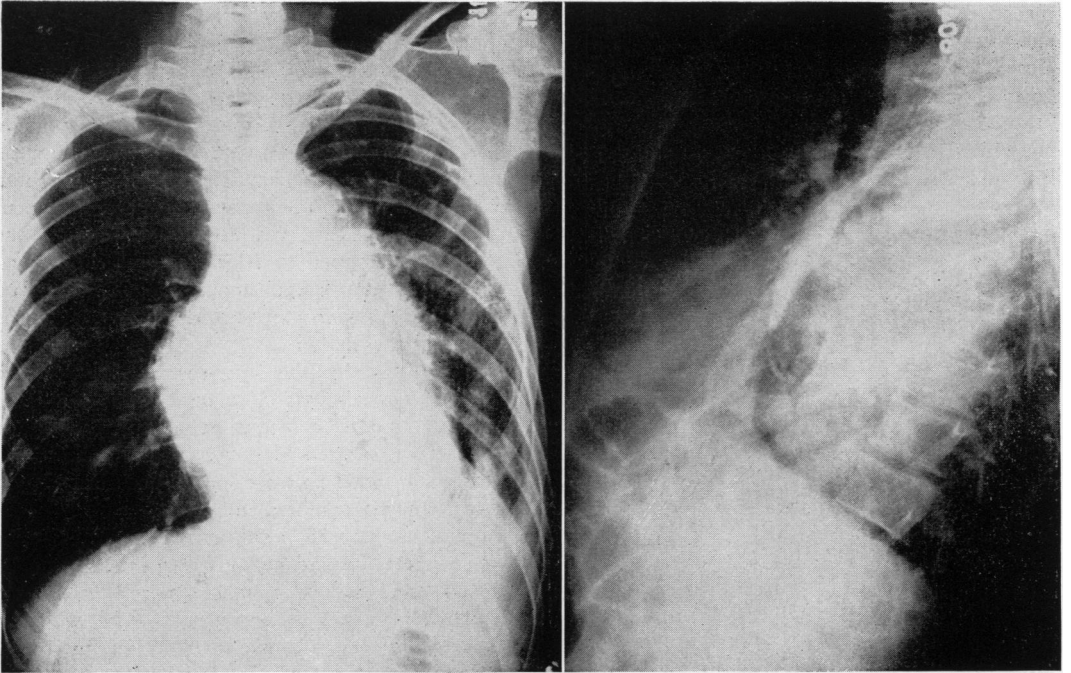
Roentgenograms taken six weeks after operation. The outline of the graft may be seen in the postero-anterior view, and the aneurysm is faintly visible in the lateral view.
